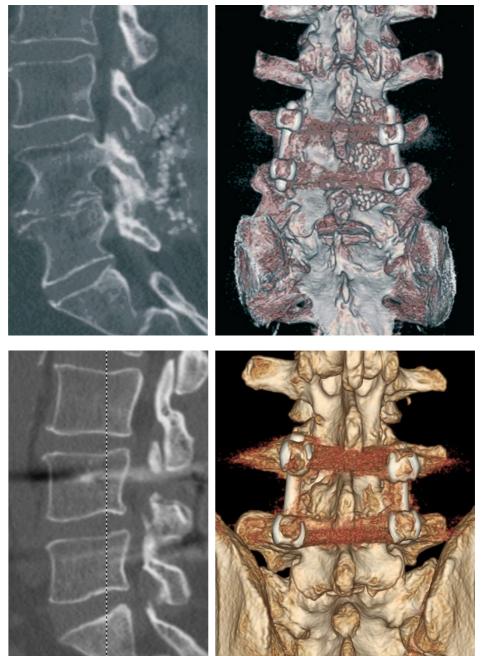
Male, 52 years old, 1 lumbar level treated between L3 and L4. Radiographic and CT scan images showing complete fusion (grade 5 Brantingan scale) at 12 months follow-up.
